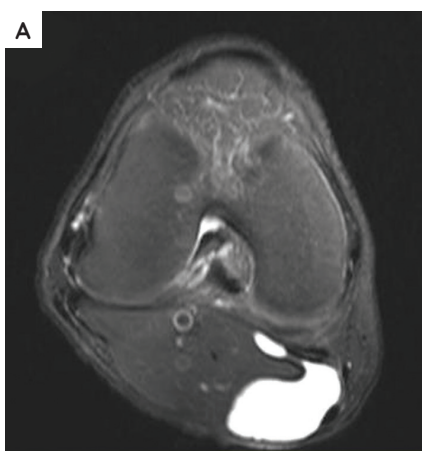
68-year-old male presenting with posterior knee pain and popliteal mass on the left knee. T2 weighted magnetic resonance images (MRI) cross section presenting a popliteal mass at the posteromedial aspect of left knee (A-B), T1 weighted MRI cross section presenting a popliteal mass at the posteromedial aspect of left knee (C). T2 weighted MRI sagittal section presenting a popliteal mass (D-F).
